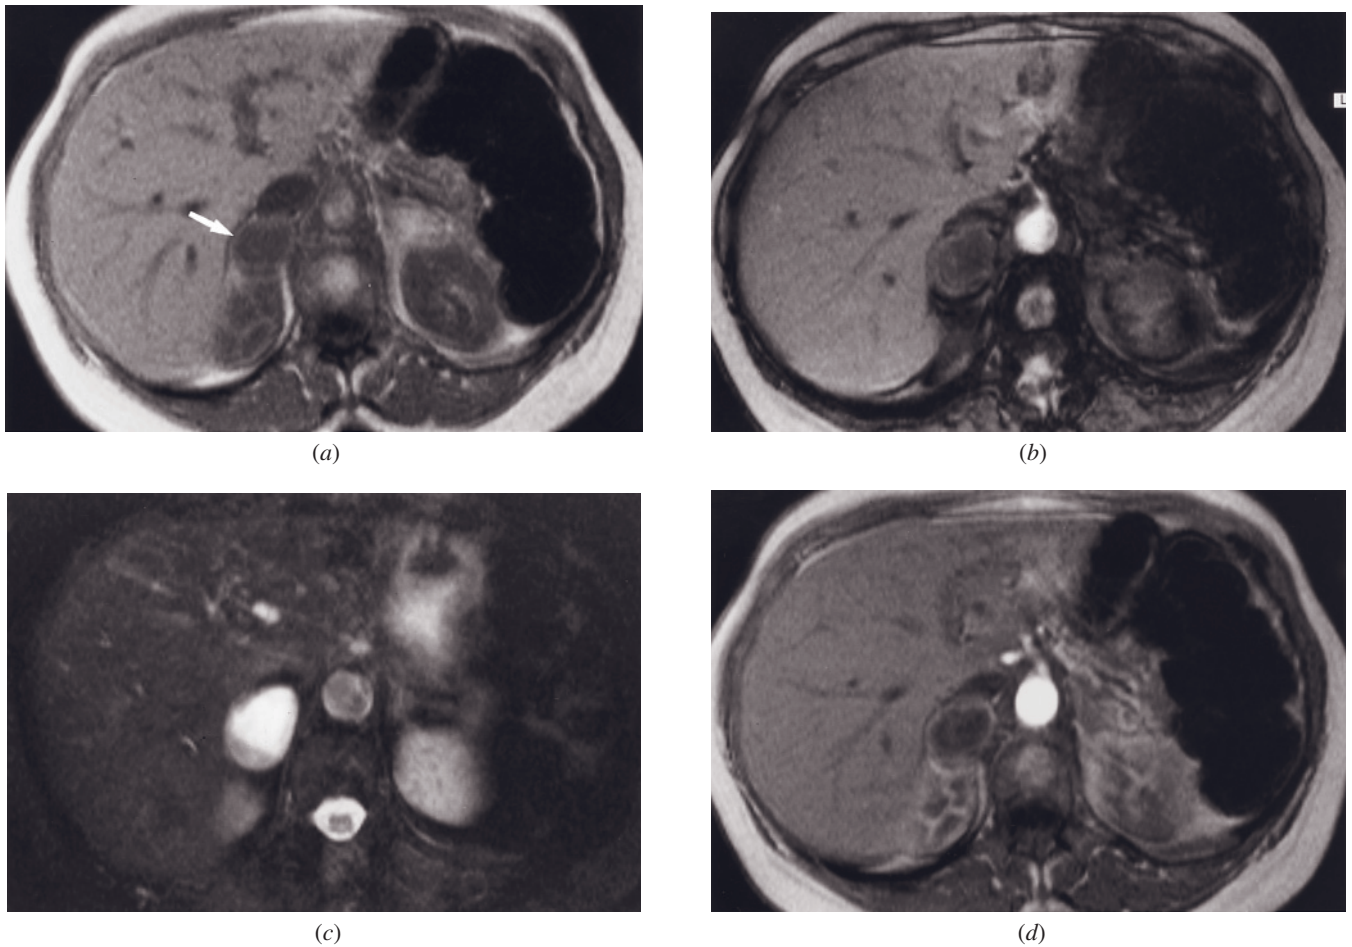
Pheochromocytoma. T1-weighted GE (a), T1-weighted out-of-phase GE (b), T2-weighted fat-suppressed spin-echo (c), immediate postgadolinium GE (d), and 2-min postgadolinium GE (*not shown*) images. A 2.5-cm pheochromocytoma arises from the right adrenal gland (arrow, a), which has a moderate-signal-intensity peripheral rim with a low-signal-intensity center on in-phase (a) and out-of-phase (b) GE images. No appreciable drop of signal intensity is present on the out-of-phase image. On the T2-weighted image, the mass is extremely high in signal intensity, with the peripheral rim appearing slightly low in signal intensity (c). On the immediate postgadolinium image, the tumor rim enhances intensely, with minimal central enhancement (d). On the more delayed image, the tumor diffusely enhances in a heterogeneous fashion (*not shown*).
